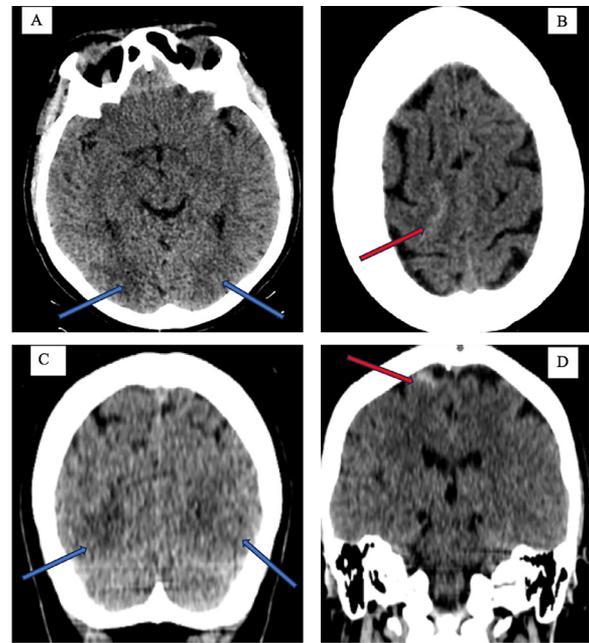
Cerebral CT scan without injection in axial section (A, B) and coronal reconstruction (C, D) showing hypodensity of the white matter of the posterior occipital regions (blue arrows) and a right frontal subarachnoid hemorrhage (red arrows).
